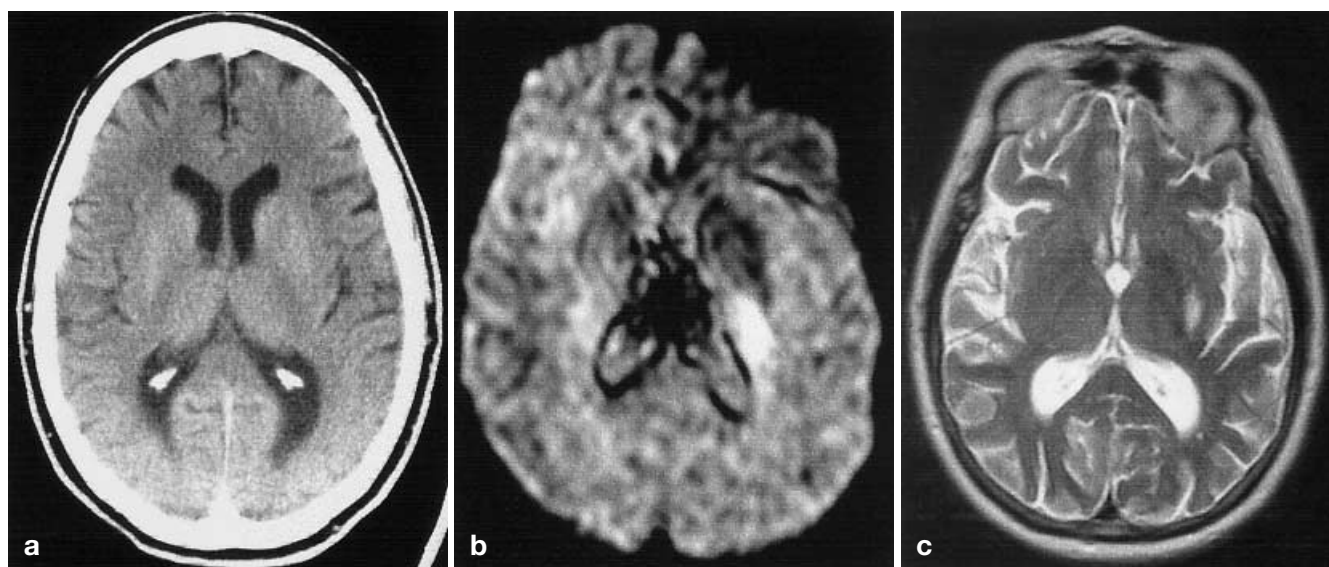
CT, diffusion- (DWI) and T2-weighted images of a 72-year-old patient first examined 2 h 15 min after onset of a right hemiparesis. DWI shows high signal in the lentiform nucleus, while CT is normal. The T2-weighted image shows the infarct in the lentiform nucleus 4 days later
